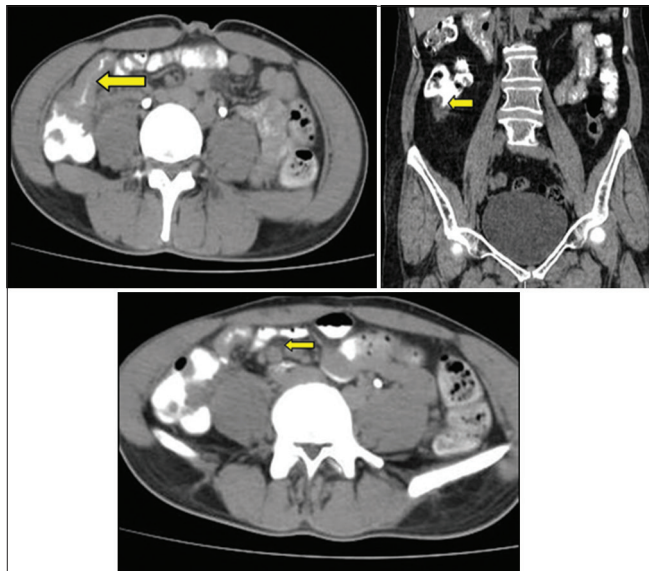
Multidetector computed tomography enteroclysis-enteroclysis in a year-old male patient showing terminal ileal wall thickening with pulled-up cecum and few enlarged mesenteric nodes
